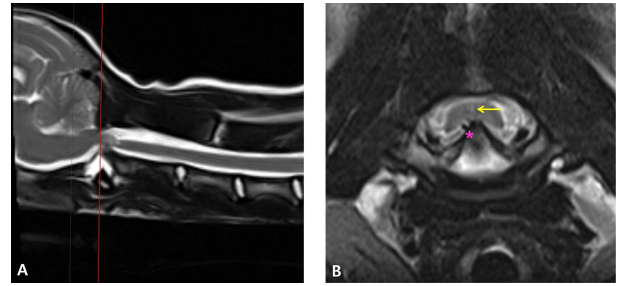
T2-weighted sagittal MRI image (A) and transverse MRI image (B) at the point of red line of (A). The yellow arrow is indicating compression of spinal cord and the purple asterisk mark is pointing to dorsal angulation of dens.
